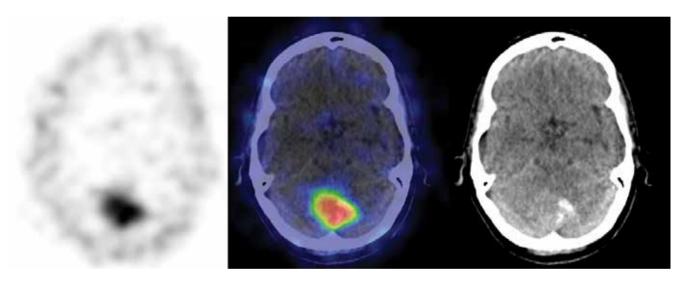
Incidental intense focal tracer uptake was revealed on SRS SPECT/CT in the posterior part in the brain. The final diagnosis was meningioma in the occipital lobe
